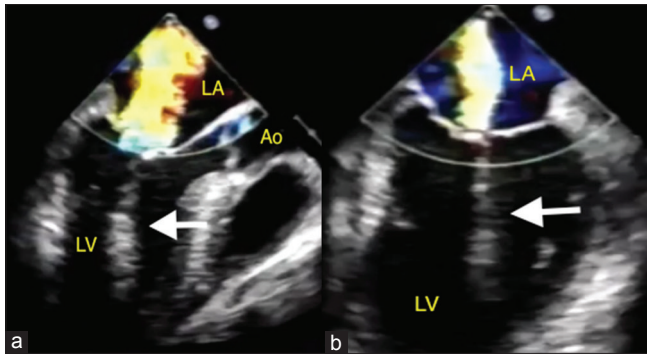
Transesophageal echocardiogram mid-esophageal long-axis (a) and two-chamber (b) views demonstrating the pacemaker wire (arrow) and mitral regurgitation. LA: Left atrium, LV: Left ventricle, Ao: Aorta
